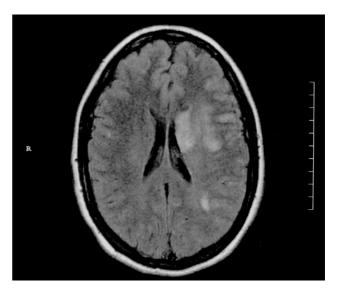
MRI demonstrating left hemisphere infarct.
